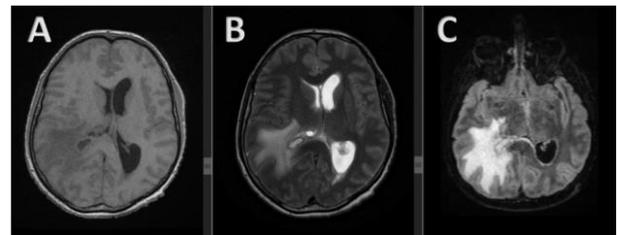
Brain MRI showing the heterogenous lesion in the right hemisphere, with extension in the right trigone of the lateral ventricle. The lesion shows central high diffusion restriction on T1 (A), T2 (B), FLAIR (C).
